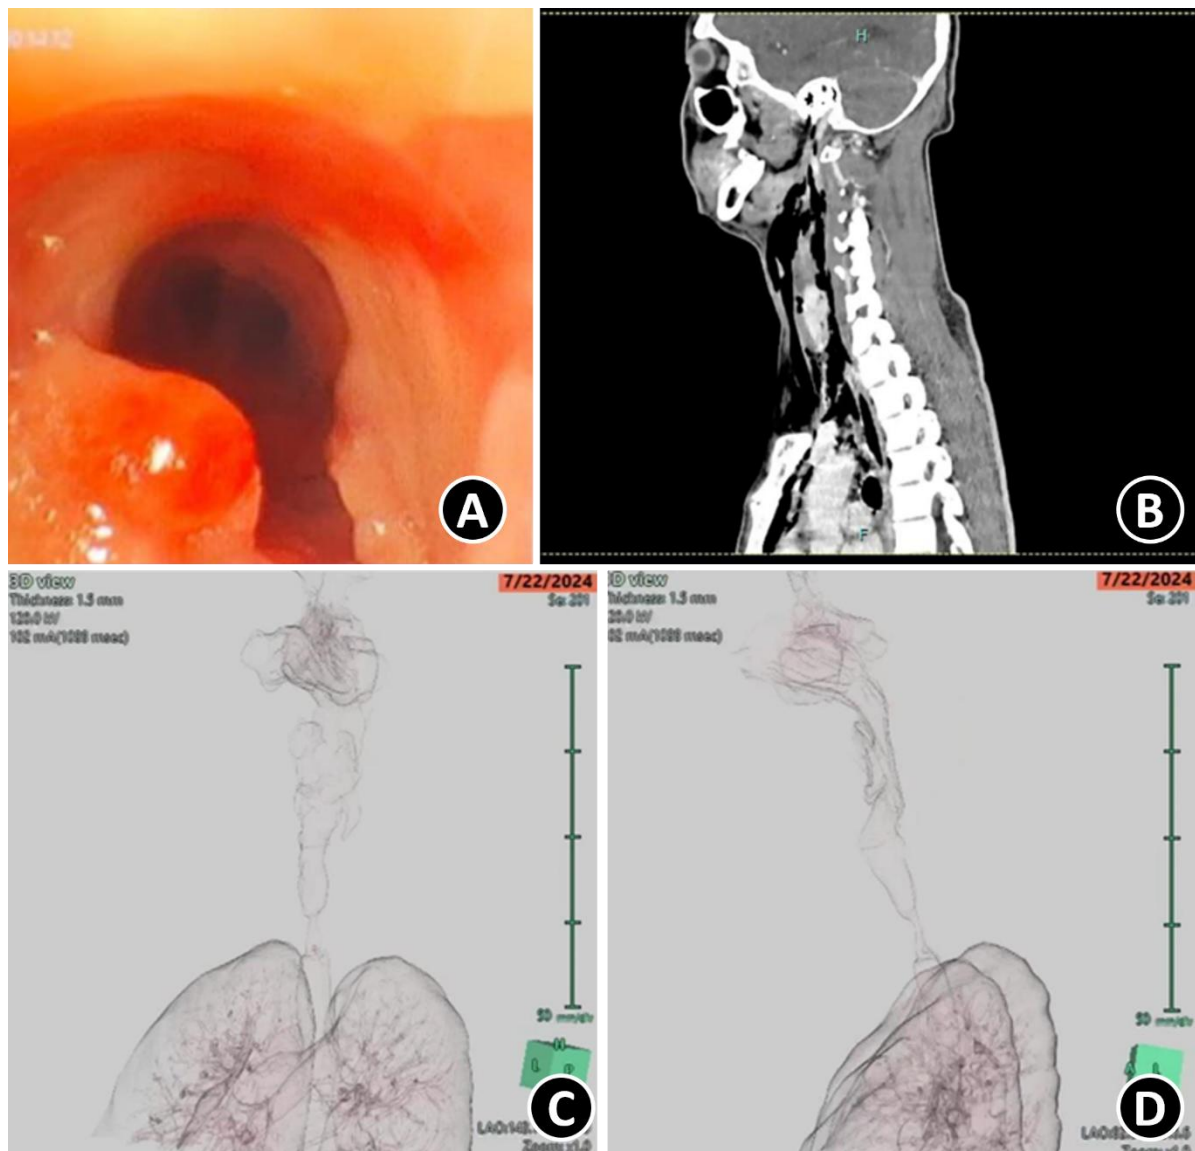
(A) A bronchoscopy visual and (B) a cervical CT scan of the patient. (A) Visualized tracheal narrowing at the level of VC 5-7, approximately 1.8 cm long, with a narrowest diameter of approximately 0.41 cm projected at the level of VC 7. Distally, the narrowing is approximately 7.7 cm from the carina. The above findings may indicate a tracheobronchial injury, with the following features (C and D): a tracheal defect of approximately 0.16 cm on the right posterolateral side at the level of VT_h 3.
